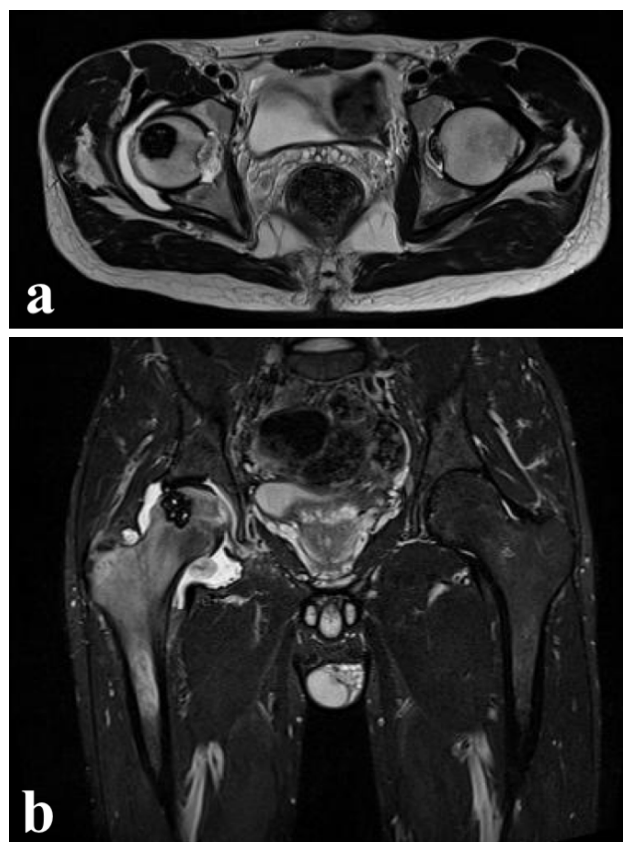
Axial T1-weighted MRI (a) and Coronal STIR (b) showing an epiphyseal osteoblastoma of the proximal femur without soft tissue extension
